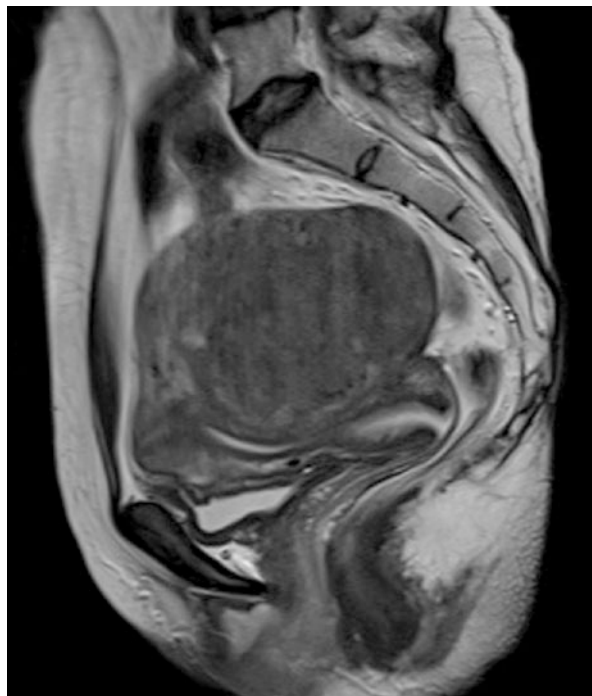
Sagittal T2-weighted MR image of a large posterior wall uterine fibroid which is compressing the uterine cavity (Image Courtesy—Dr. Karthik Ganesan, Mumbai)
